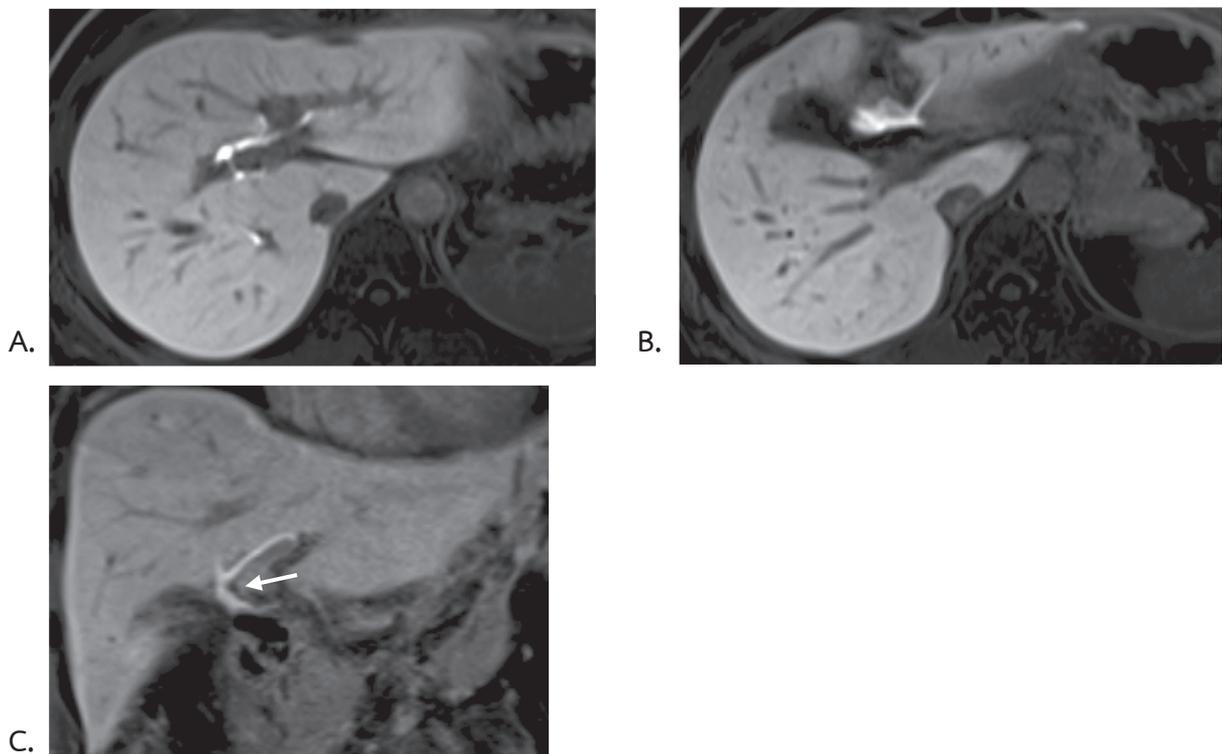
MRI and MRCP of the patient in figure 1 after percutaneous drainage of biloma, obtained 30 minutes after intravenous injection of gadoxetate disodium. (A) There was much decreased intra-abdominal fluid collection. Evidence of contrast excretion within bile ducts was observed. (B, more caudal than A) Contrast accumulation at hilar region was seen. (C) Coronal views showed the region of contrast extravasation adjacent to the common hepatic duct (arrow).
